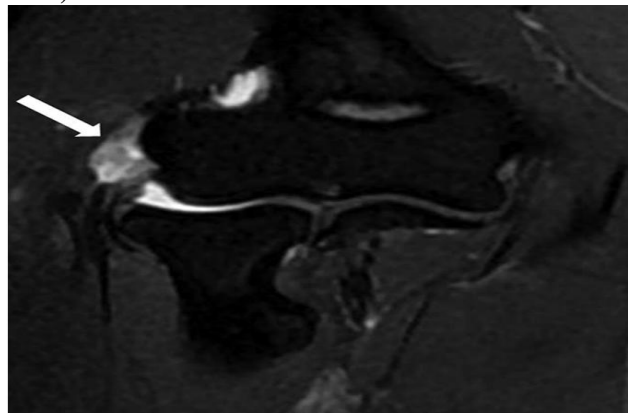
42-year-old woman with right elbow pain 2 years (Tendinopathy score $\frac{1}{4}$ 3; PRTEE score $\frac{1}{4}$ 89). Coronal T2-weighted fat-suppressed MR image shows a generalized increase in the tendon signal (white arrow). PRTEE $\frac{1}{4}$ Patient-Rated Tennis Elbow Evaluation
